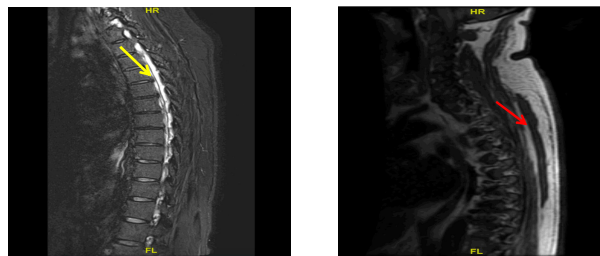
MRI of the spine showing (A) epidural empyema (yellow arrow), spinal stenosis, and compression of the cervical and thoracic spinal cord with posterior empyema extending from C1 to L2. (B) 6-months later, empyema resolved (red arrow), showing no evidence of enhancing fluid collection or abscess.
